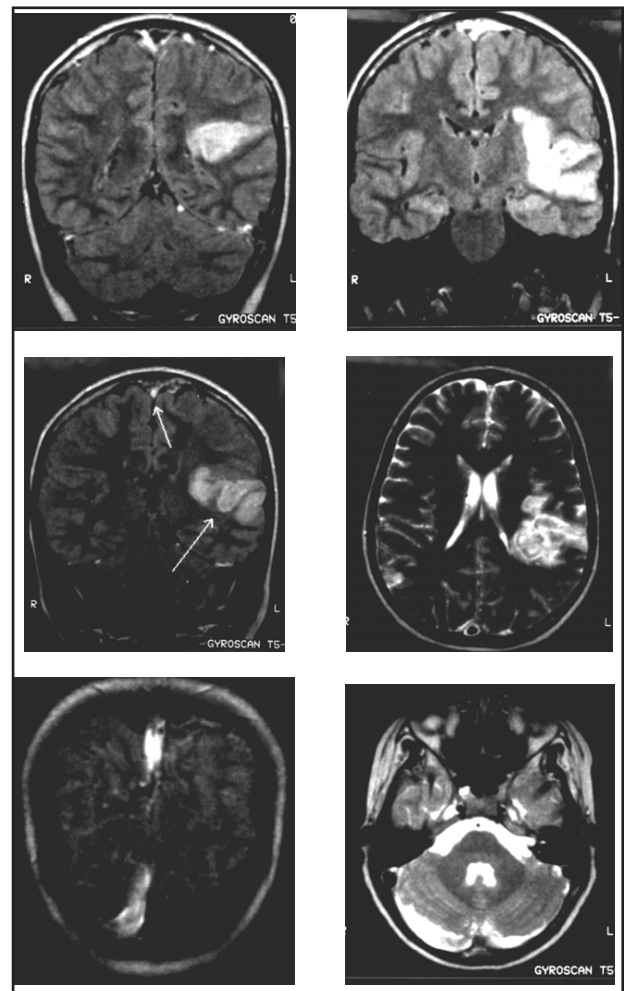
Cranial MRI images
